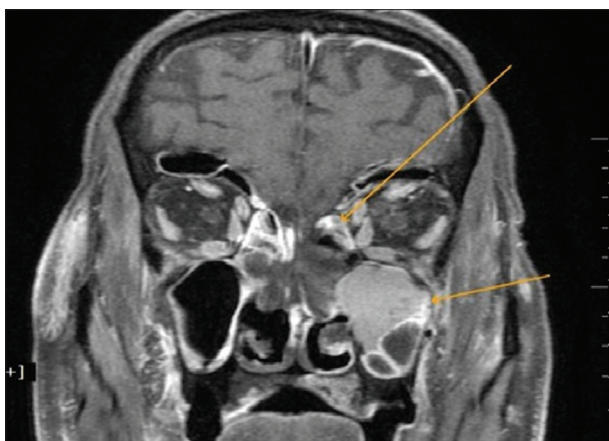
Magnetic resonance imaging image showing maxillary and ethmoid sinusitis
